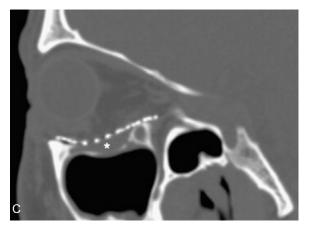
Images of the use of 3D printing in orbital reconstruction surgery Fig. 10A: Image of using a 3D printed left orbital floor model to shape a titanium mesh before the surgery. Fig. 10B: Left orbital floor reconstructed by pre-shaped titanium implant. Fig. 10C: CT image of the left orbit after reconstruction surgery showing the restored orbital volume of patient's reconstructed left orbital floor. Permission granted from Fig. 5-7 of.³⁶
